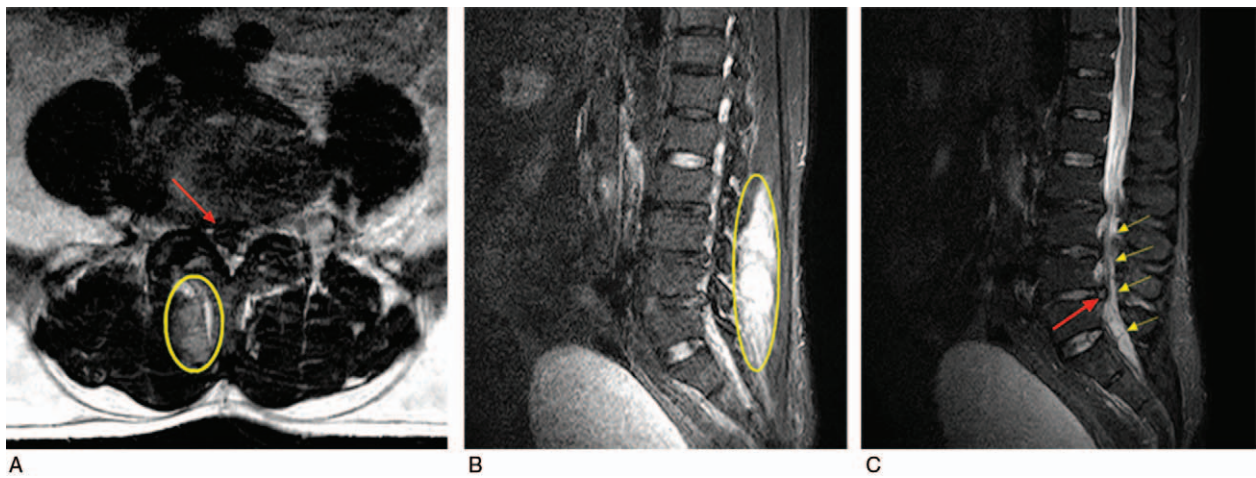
The urgent imaging examination. Axial (A) MRI shows L4 to L5 lumbar disc herniation, and sagittal (B and C) MRIs show epidural and paravertebral abscesses at the L3 to S1 vertebral levels. (Red arrow, yellow circle, and yellow arrow indicate lumbar disc herniation, paravertebral abscess, and epidural abscess, respectively.). MRI=magnetic resonance imaging.
